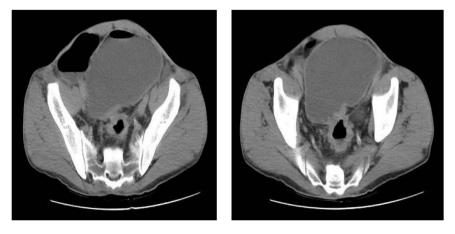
Abdominal CT axial section without PDC injection showing a transition zone of stenosing thickening (white arrow) of the recto sigmoid hinge.
